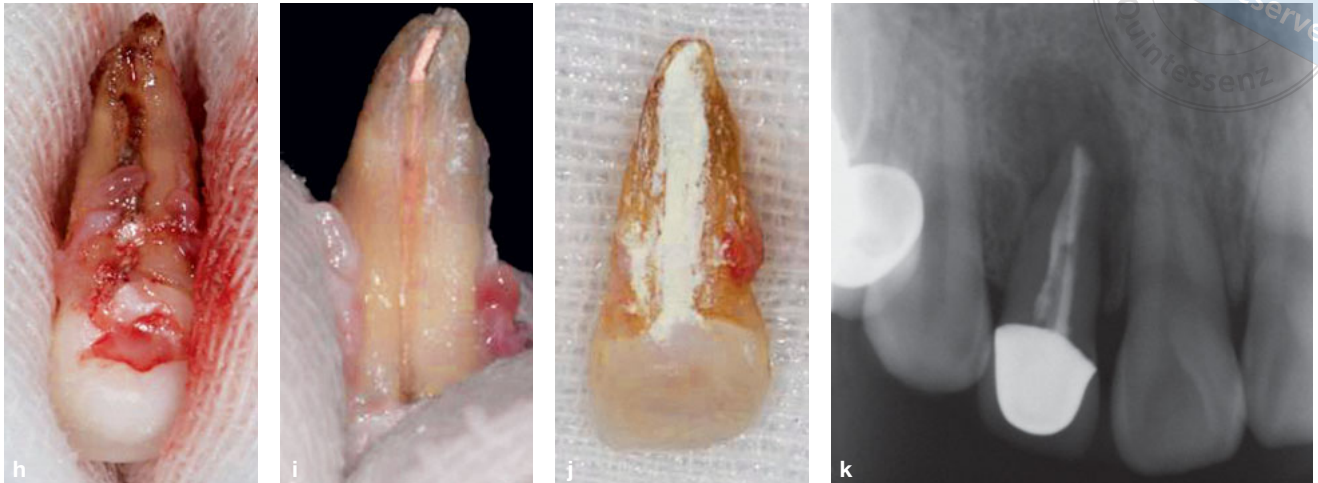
(cont.) (h) A palatogingival groove was clearly revealed and found to extend from the coronal third to the apical third of the root. (i) The palatogingival groove was removed with a diamond bur. (j) The palatogingival groove and root apex were filled with MTA. (k) Radiograph taken after intentional replantation.
